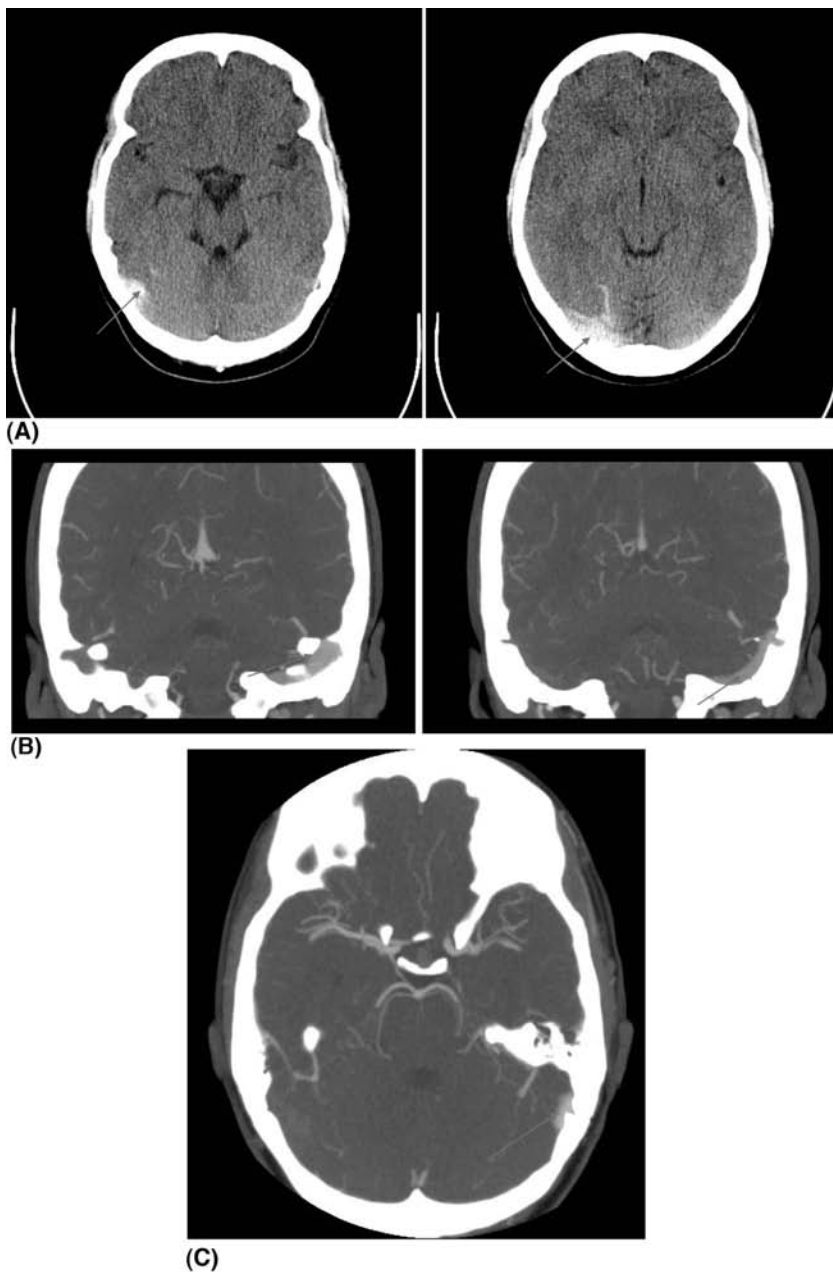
A 28-year-old woman who whilst 16 weeks pregnant developed sudden onset of headache and nausea. (A) CT brain scan showing hyperdense transverse and sigmoid sinuses. (B) coronal and (C) axial CT venograms demonstrating that there is no filling of the right lateral transverse sinus and sigmoid sinus due to venous sinus thrombosis.
